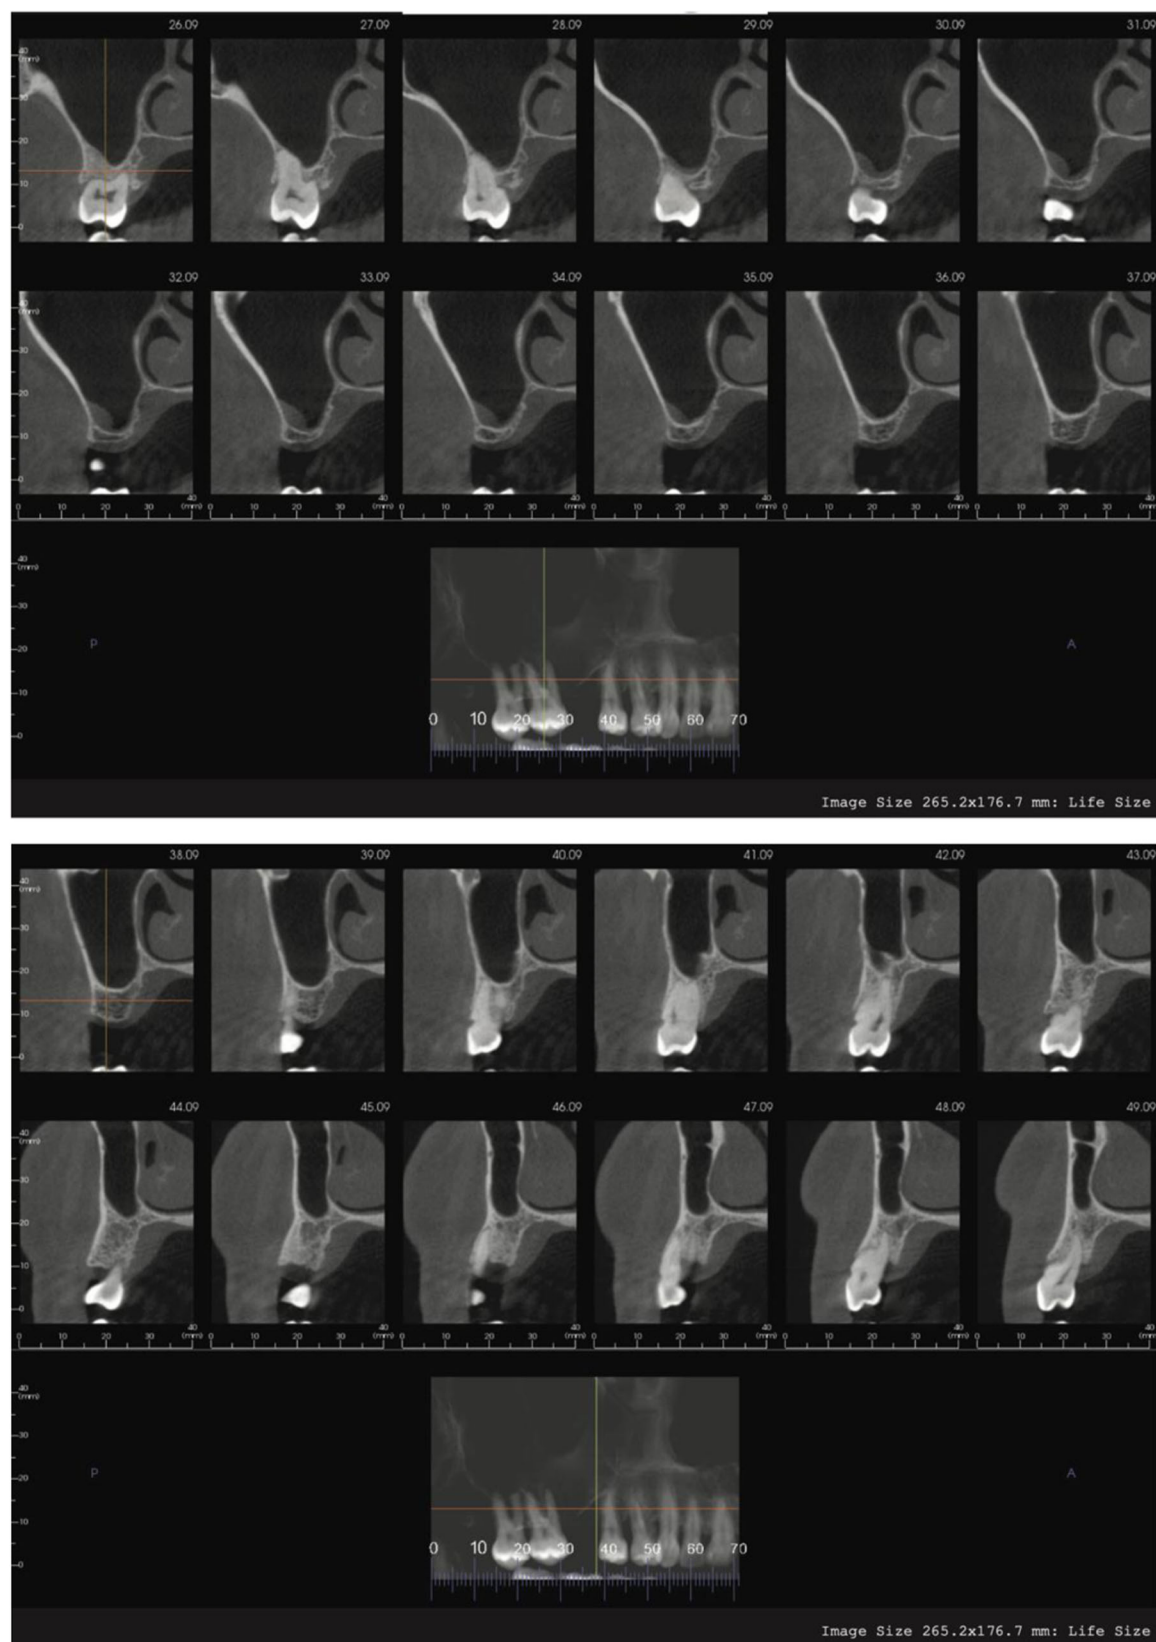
Preoperative CBCT of #3 site
